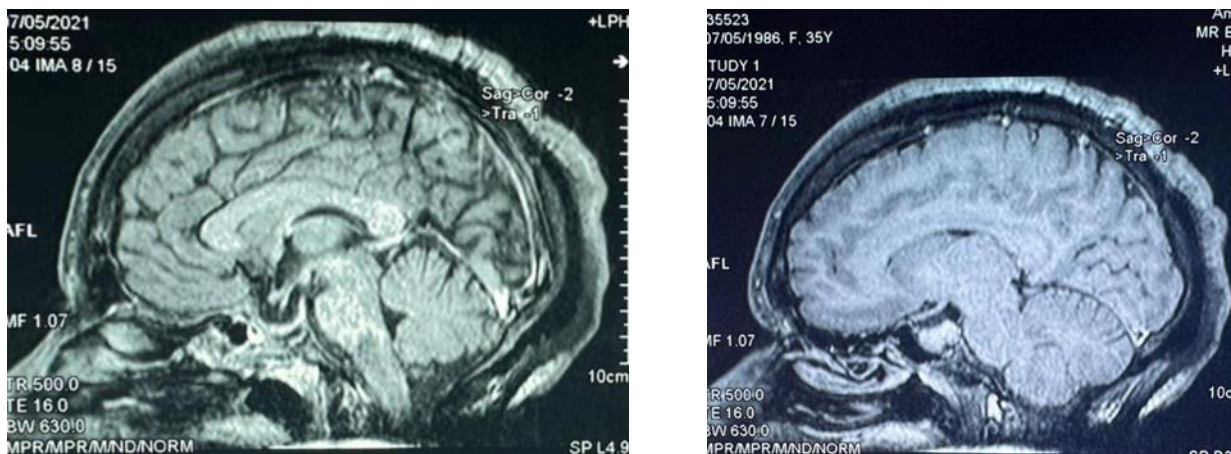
and 2 Pituitary MRI revealing the tumor in the sella and along the stalk measuring 20.8 x 17 x 28.8 mm
